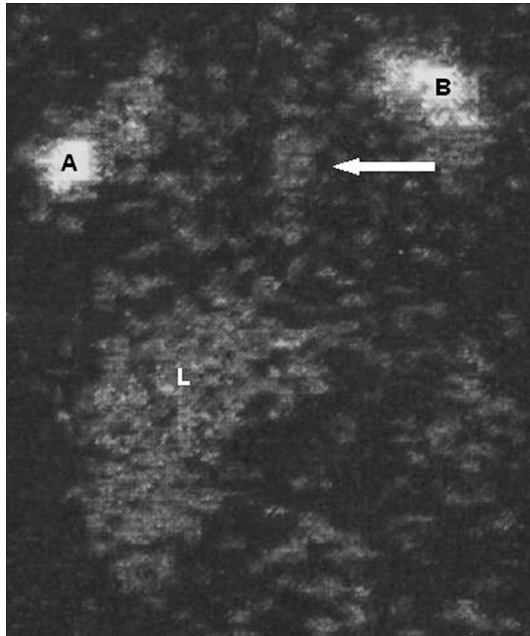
Lymphoscintigraphy in a newborn affected by pulmonary lymphangiectasia and generalized lymphedema. A, B, and L indicate the right axillary lymph nodes, left axillary lymph nodes, and liver, respectively. The arrow indicates the thoracic duct. Signs of backflow were evident in the thoracic duct with accumulation of the radiocolloid. Diffusion of the tracer in the abdomen and the thorax is also evident, although to a lesser degree. This image is of a male patient, who presented with severe respiratory distress at birth. Respiratory problems mandated transportation to the intensive care unit where immediate intubation, artificial ventilation, and bilateral surgical drainage were performed. After initiation of enteral feeding on the third day, chylothorax was diagnosed. Thoracic radiographs showed increased interstitial markings, and High Resolution Computed Tomography confirmed the diffuse thickening of the interstitium, both of the peribronchovascular interstitium, and the septa surrounding the lobules.
